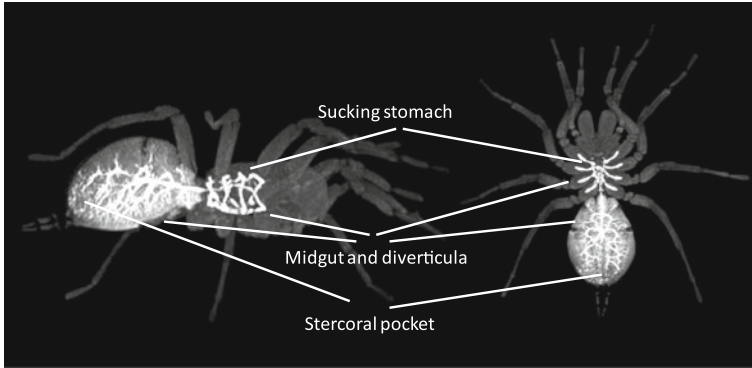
Lateral and coronal view of the gastrointestinal tract of the tarantula (*Acanthoscurria geniculata*) visualized using MRI. The midgut is visually enhanced following ingestion of MRI contrast agent. The midgut branches in both the front (prosoma or cephalothorax) and anterior (opistosoma or abdomen) and in the abdomen these branches become more diffuse and subdivide into lobules. Pictures are modified from (Lauridsen et al. 2011). See (Foelix 1996) for more detailed anatomical descriptions of the spider's digestive apparatus
